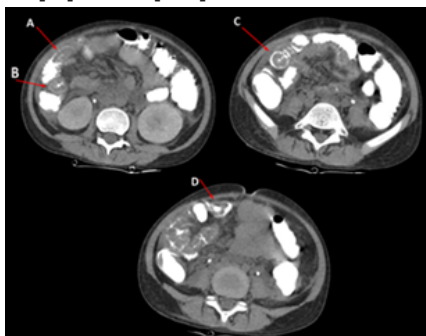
Axial CT images showing four small bowel intussusceptions with classic target signs (red arrows): A-C: Ileoileal (A, B - right lumbar; C - right iliac fossa); D: Ileojejunal (right paraumbilical).
